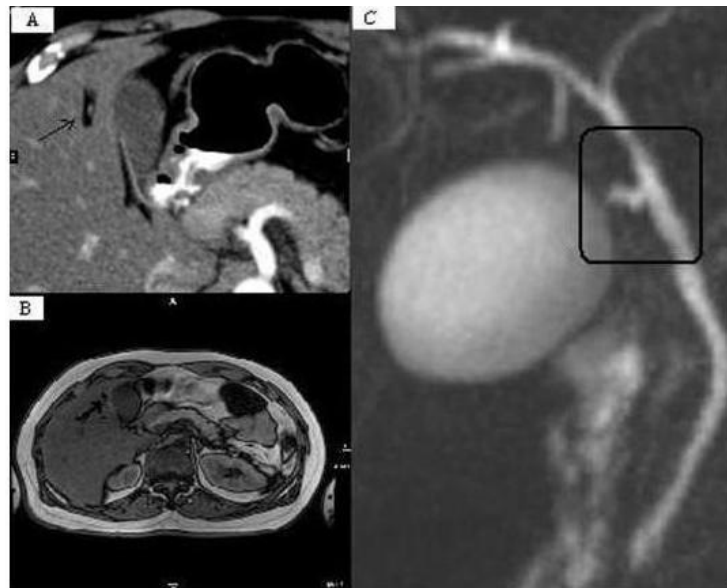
Preoperative radiological imaging of upper abdomen of patient; black arrows show round ligamentum of liver where the gallbladder is located medial to it (A: Computed Tomography, B: Abdominal Magnetic Resonance Imaging) and MRCP (C) shows normal anatomic joining of cystic duct to hepatic duct.
